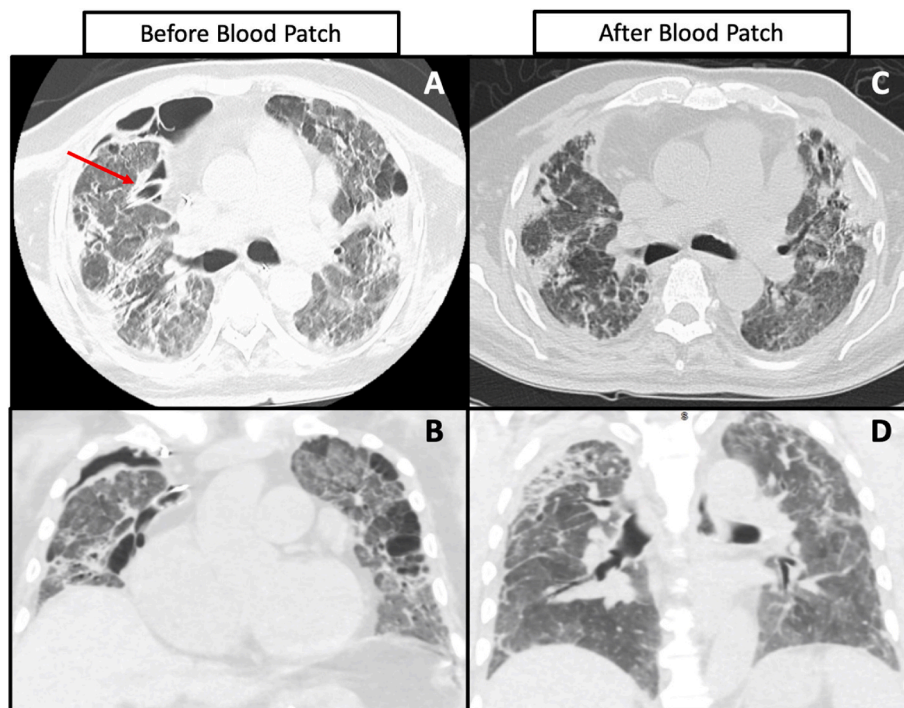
CT Chest Axial and Coronal views pre- (A and B) and post- (C and D) blood-patch repair. The red arrow in Image A indicates the distal end of the surgical chest tube in the pre-repair image. (For interpretation of the references to colour in this figure legend, the reader is referred to the Web version of this article.)
